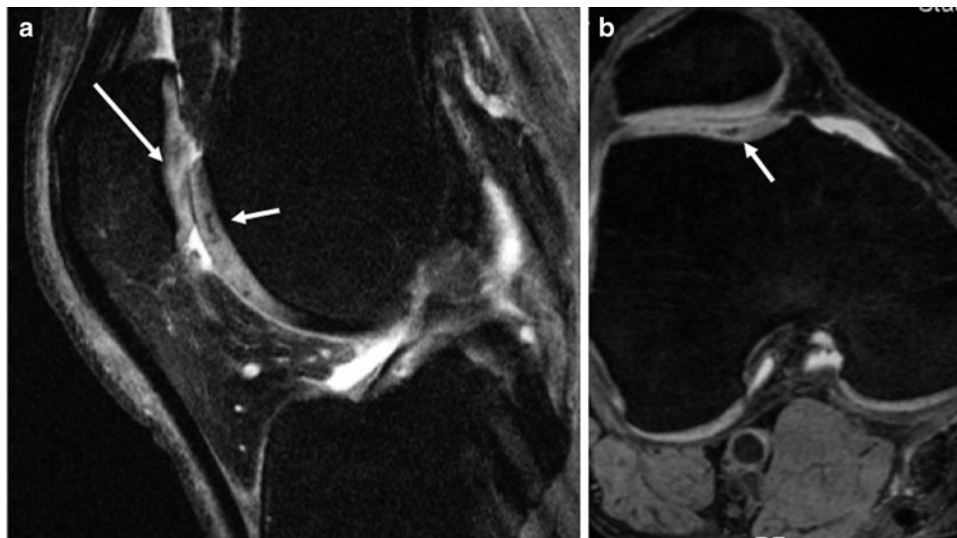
Sagittal 3D DESS MRI (16.3/4.7 ms, flip angle: 25°) of the knee obtained in a 50-year-old man (a) and axial reconstruction from the image dataset (b). Note femoropatellar cartilage degeneration
